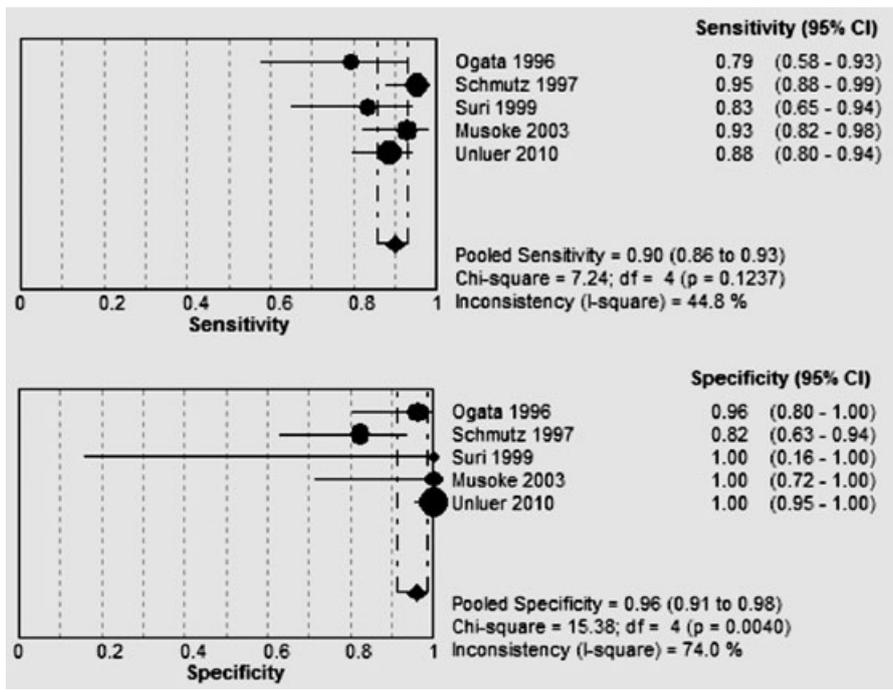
Meta-analysis of studies assessing formal US for SBO diagnosis. SBO = small bowel obstruction; US = ultrasound.
